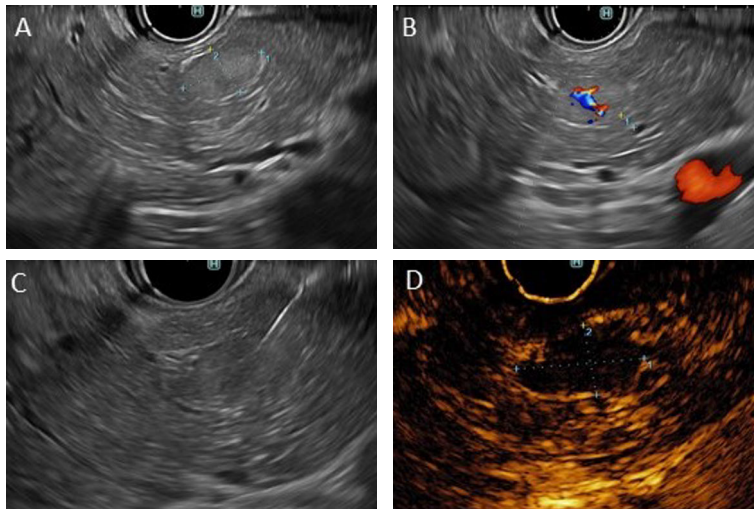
Radiofrequency ablation (RFA) of an insulinoma measuring 13 x 8 mm using endoscopic ultrasonography (Hitachi) (A). Doppler imaging demonstrated hypervascularity with a distance of 2.8 mm from the main pancreatic duct (B). The RFA needle inside the tumor (C). Following ablation, the tumor tissue appeared avascular when visualized using the SonoVue® contrast agent (D). Images on courtesy of Hannes Kortekangas, Abdominal Centre, Turku University Hospital, 2021.
